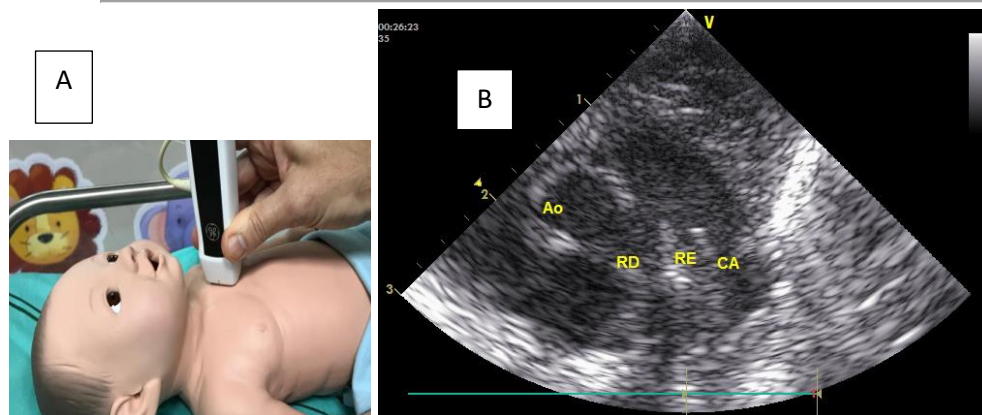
Ductus window, with an intercostal space positioned above the parasternal short axis window. Ao: aorta, RD: right branch of pulmonary artery, RE: left branch of pulmonary artery, CA: ductus arteriosus.
